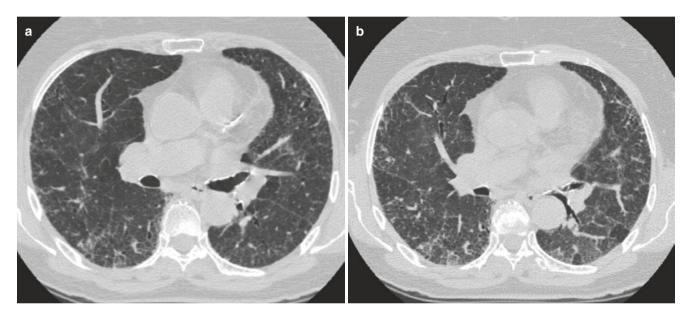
Hypersensitivity pneumonitis. (a) Inspiratory and (b) expiratory CT images show fibrosis and air-trapping
